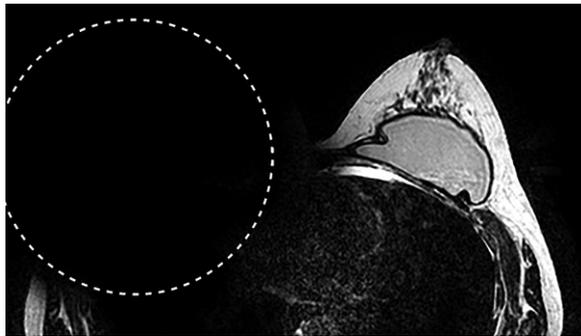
Axial T2-weighted MR image of the breasts shows a large susceptibility artifact (dashed circle) caused by a magnetic localization device within an implant tissue expander, which resulted in complete nonvisualization of the right breast and chest wall.
